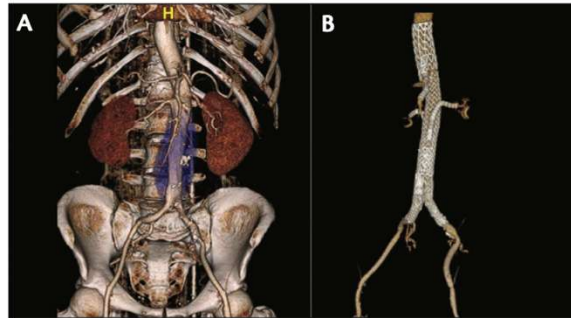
The second worldwide case performed in Florianopolis, Brazil, by Dr. Pierre Galvagni and colleagues at the Universidade Federal de Santa Catarina. Preoperative (A) and postoperative (B) CTA demonstrating widely patent stent-grafts and no endoleak at 1 year.
